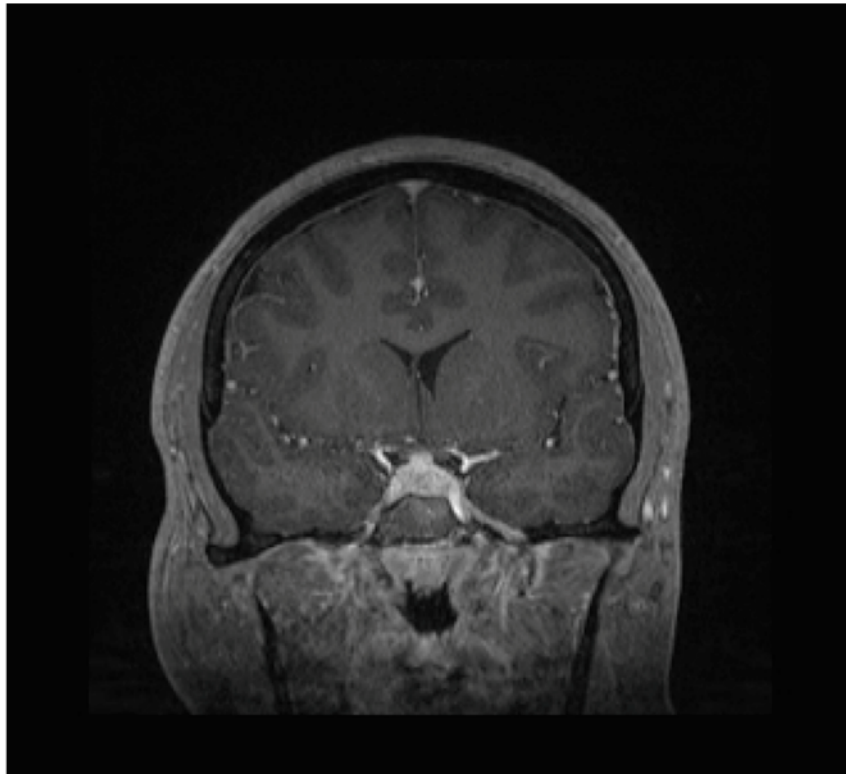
Post-contrast T1-weighted image with fat suppression demonstrating an enhancing sellar/suprasellar mass.
